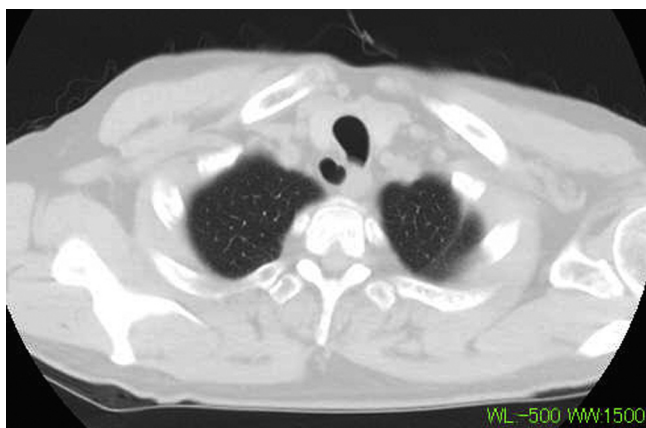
A CT scan performed 4 years previously showing a tracheal diverticulum in the same position as the mass.
